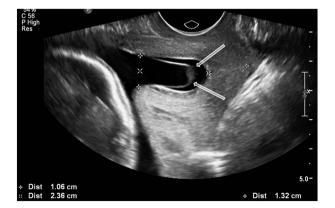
Transvaginal ultrasound of a shortened cervix with arrows pointing to detachment of fetal membranes.
